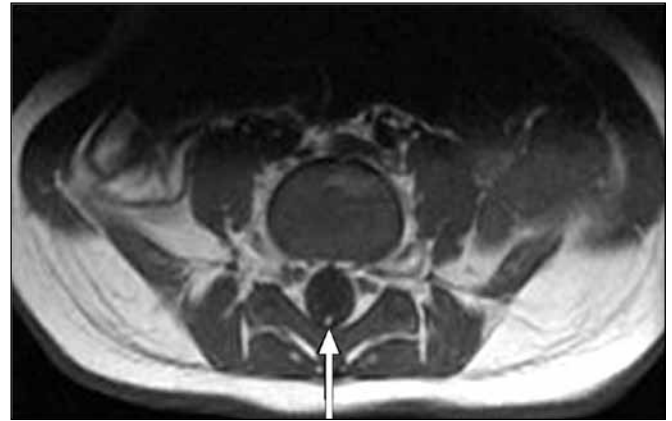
Axial-T1 MR image shows lipoma of the filum terminale (arrow) as a high-signal intensity round structure in the thecal sac.
